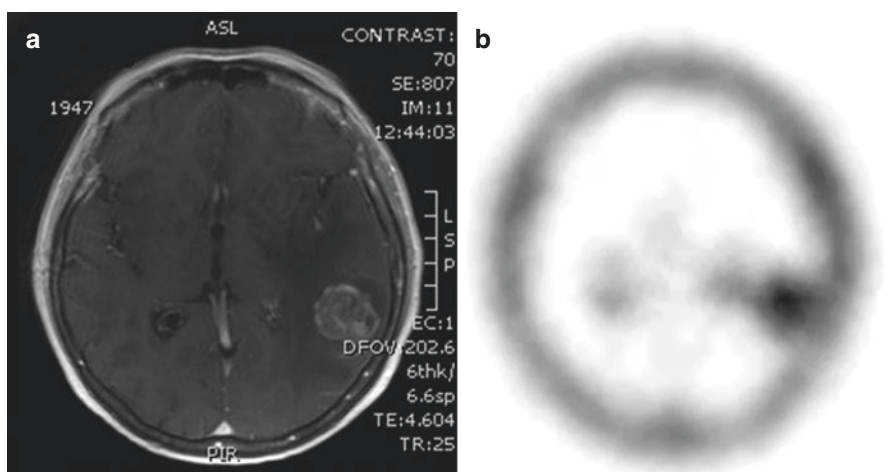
(a) T1-weighted MRI after gadolinium infusion in a patient with a metastatic lesion. (b) ^{99m}Tc -tetrofosmin brain SPECT revealing increased tracer uptake in the corresponding area
